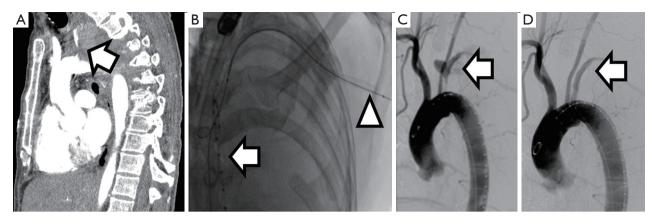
A 60-year-old man with epithelioid malignant mesothelioma status post left pleurectomy decortication, resection of the diaphragm, and posterior mediastinal lymph node dissection with adjuvant radiation to the left hemithorax. The patient presents to the emergency room with large volume hemoptysis, left shoulder pain, and left upper extremity pallor and numbness. A CT demonstrated a pseudoaneurysm in the left subclavian artery with bronchial fistula and pleural cutaneous fistula (A, arrow identifies pseudoaneurysm with adjacent mediastinal and parenchymal hematoma). Arterial access was achieved via both a femoral and left brachial access (B, arrow and arrowhead respectively). Angiograms through the bilateral accesses confirmed and further characterized the pseudoaneurysm (C, arrow). A stent was successfully placed via the left brachial artery access, with occlusion of the pseudoaneurysm and reconstitution of blood flow (D, arrow). CT, computed tomography.
